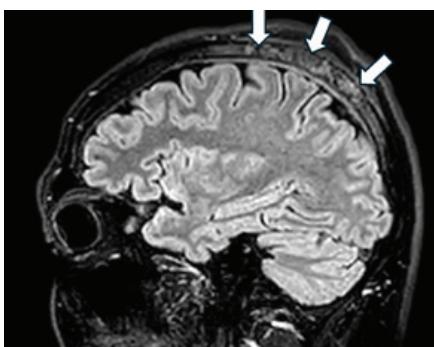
Brain MRI (FLAIR sequence), sagittal slice – foci of bone remodeling in the parietal bones
